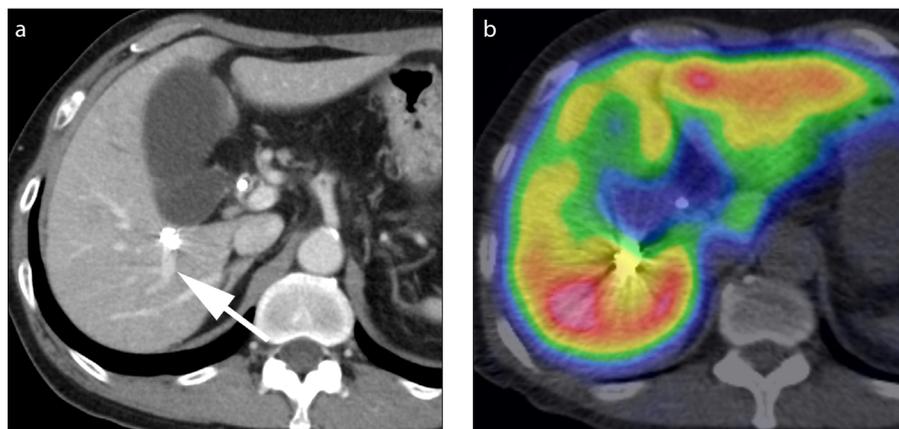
a, b. Contrast-enhanced CT and ^{99m}Tc -GSA SPECT/CT fusion imaging of a patient with recanalized portal branch. Contrast-enhanced CT image (a) with SEMAR reconstruction three weeks after both PVE and coil embolization: although coil embolization of both the anterior branch and posterior branch were performed, the posterior branch was recanalized (arrow). ^{99m}Tc -GSA SPECT/CT fusion imaging (b) shows preserved uptake of ^{99m}Tc -GSA in the liver segment corresponding to the recanalized portal branch.
